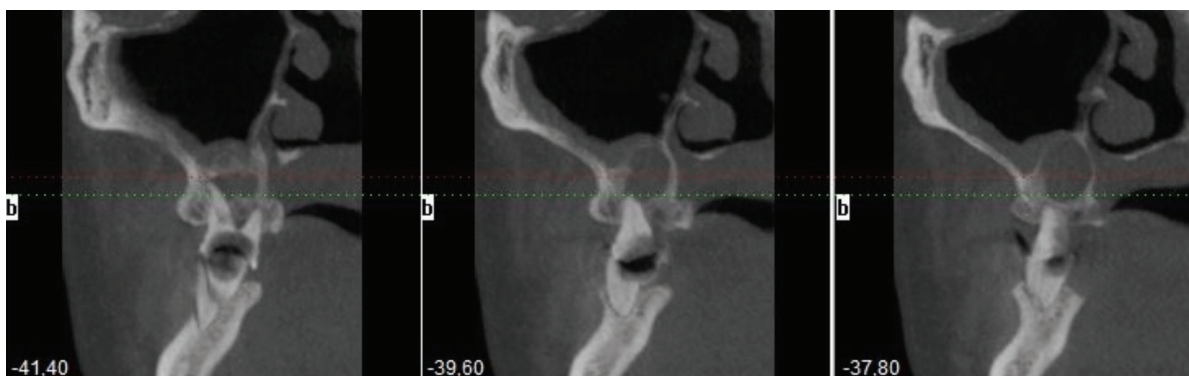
Element 1.6 CBCT frames.
